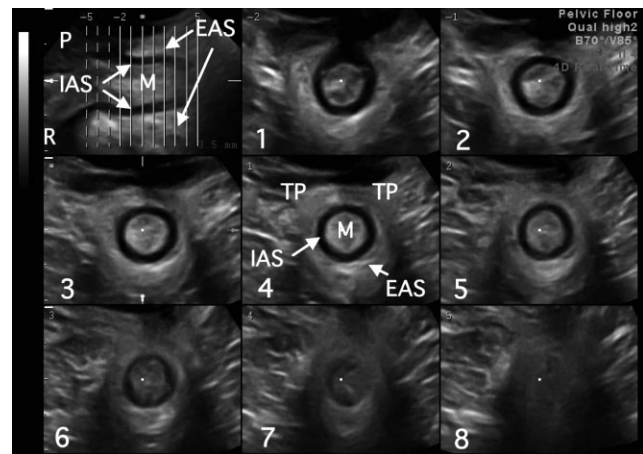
Normal appearance of anal sphincter complex on multislice or tomographic ultrasound imaging. A set of eight slices is obtained to encompass the entire external anal sphincter (EAS) by placing one slice cranial to the EAS (at level of puborectalis, Slice 1) and another caudal to the internal anal sphincter (IAS) (at level of subcutaneous part of EAS, Slice 8), leaving six slices to delineate the entire muscle (Slices 2–7). Interslice interval is varied depending on EAS dimensions. M, anal mucosa; P, perineal body; R, rectum; TP, transverse perineal muscle.
